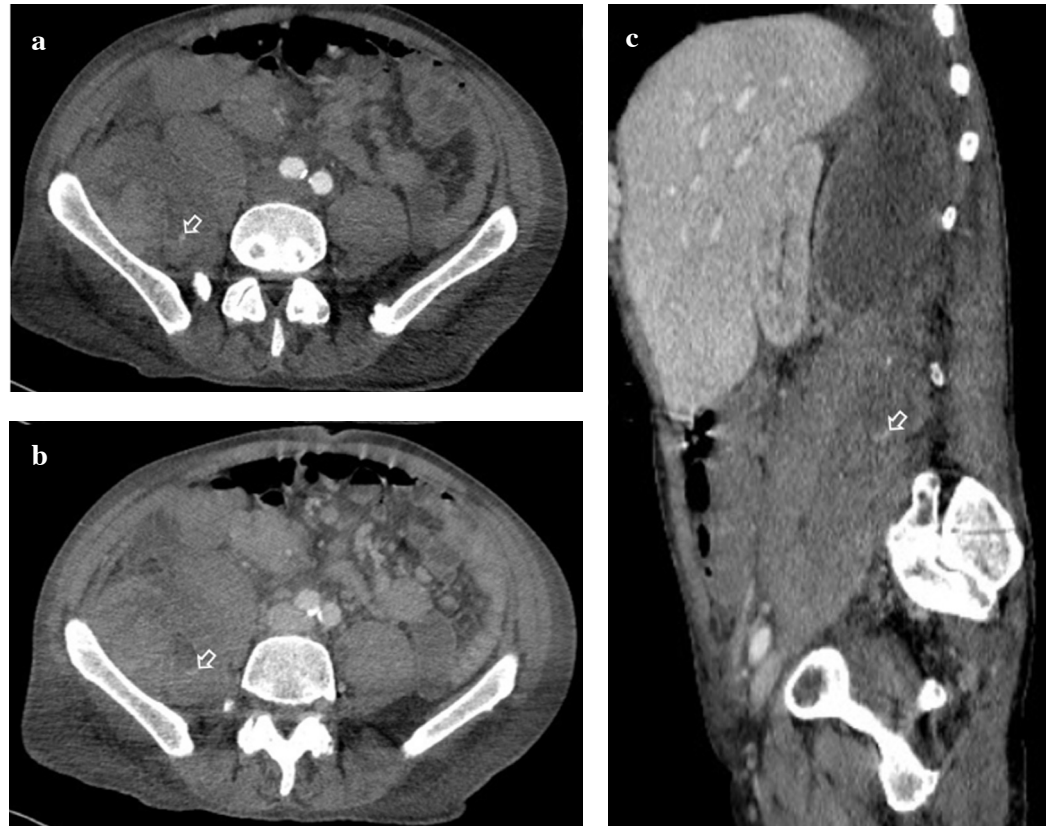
a-c. CT scan in arterial phase (a), venous phase (b) and sagittal multiplanar reconstruction in venous phase (c) shows voluminous retroperitoneal hematoma of the right iliopsoas muscle with leaking of contrast medium (arrow in a, b and c)
